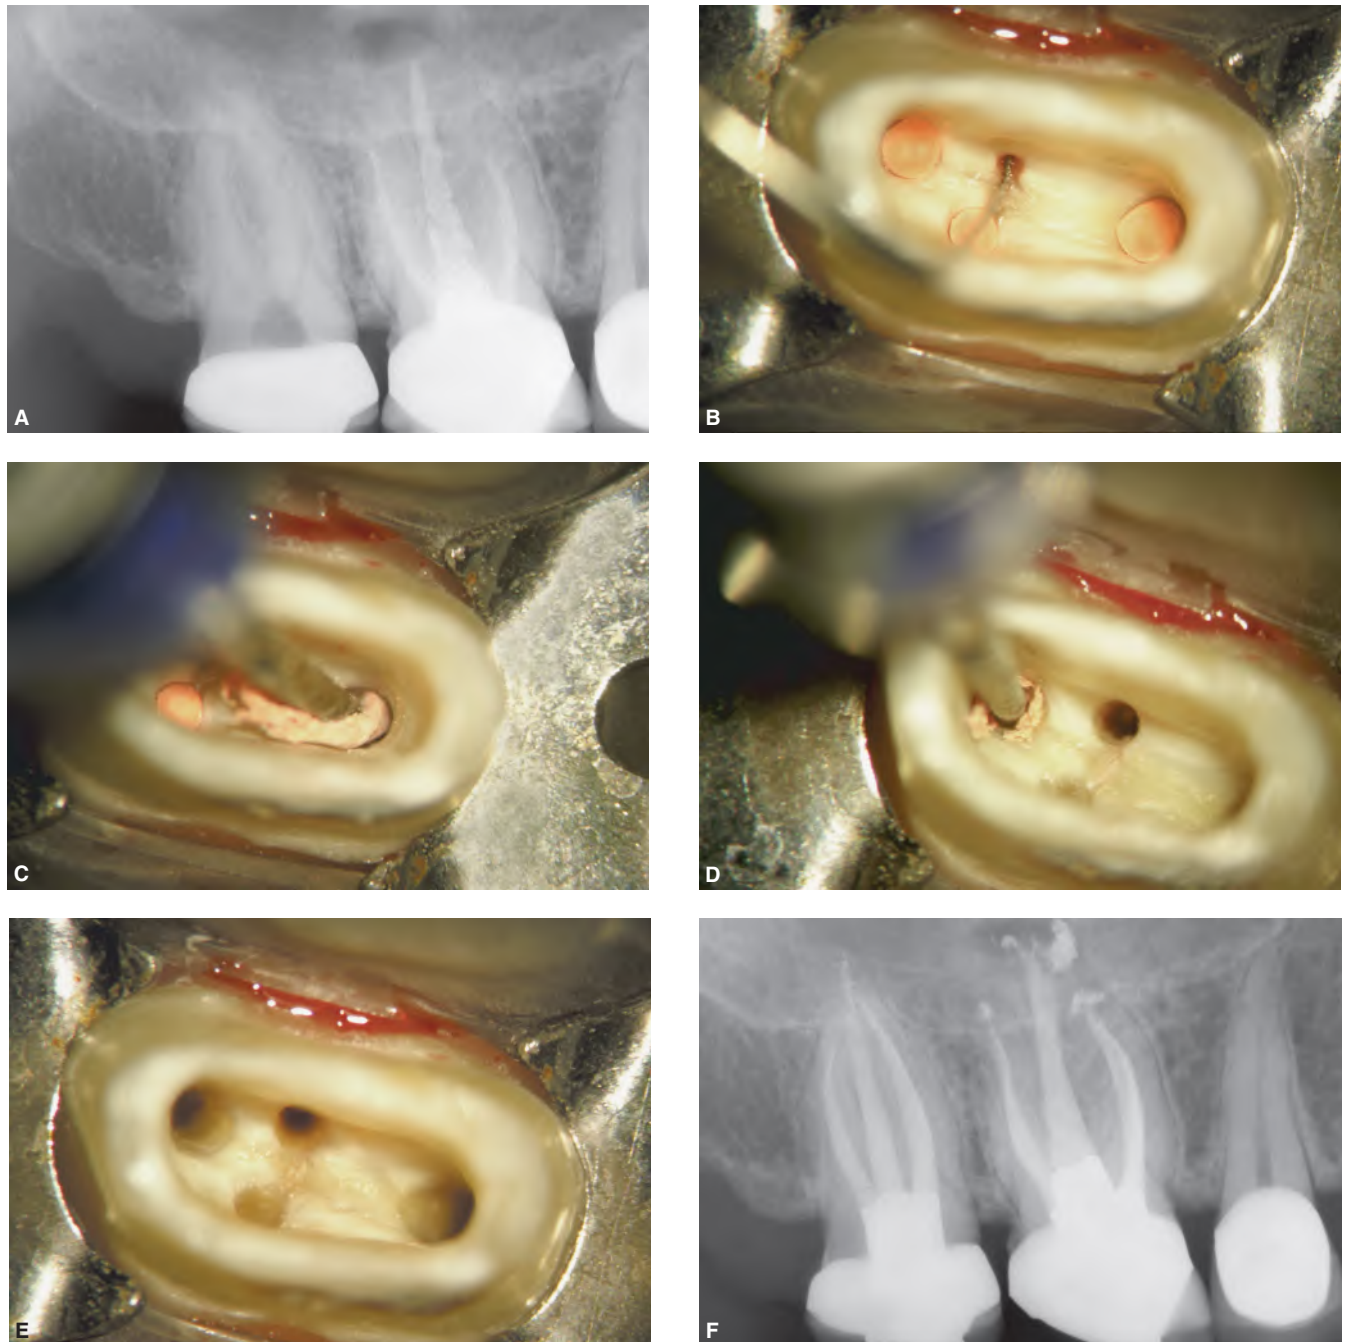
A. Radiograph of a failing endodontic treatment in a maxillary right first molar showing that the previously treated canals are underfilled and underextended. B. Photograph at 15× magnification demonstrates crown removal, straightline access, and the identification of an MB-2 system. C. Photograph at 15× magnification demonstrates removal of gutta-percha from the palatal canal with a .06 tapered NiTi rotary profile. D. Removal of gutta-percha from the mesiobuccal canal with a smaller sized .06 tapered NiTi rotary profile. E. Pulpal floor and orifices following canal preparation procedures. F. Postoperative radiograph demonstrating the value of nonsurgical retreatment and its potential to address root canal systems and improve quality of treatment.
